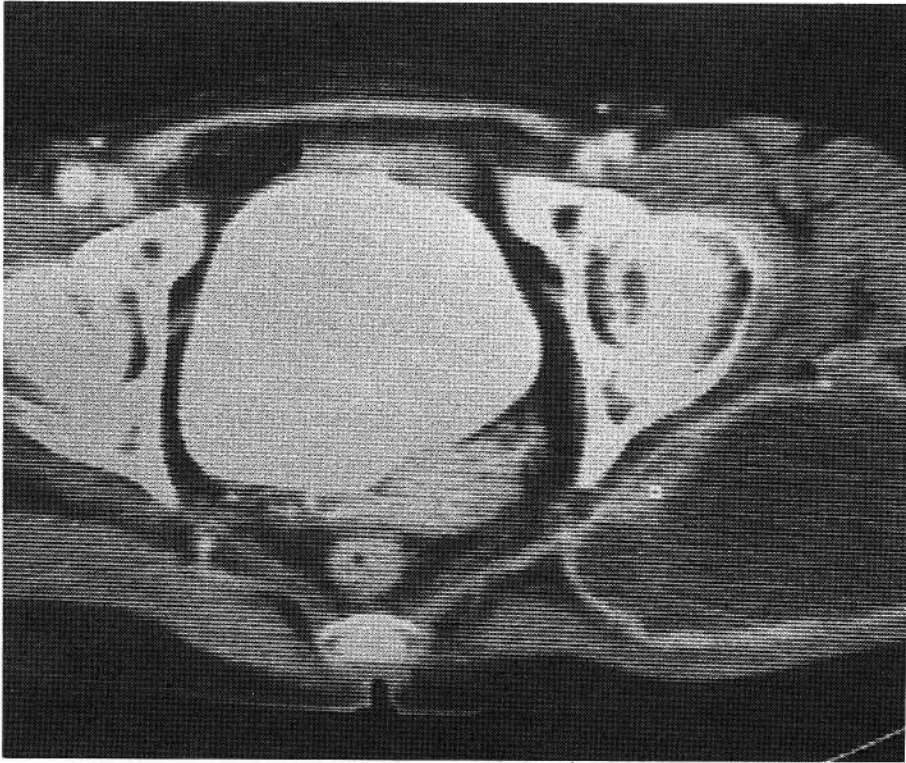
CT scan 4 months after TAE.
